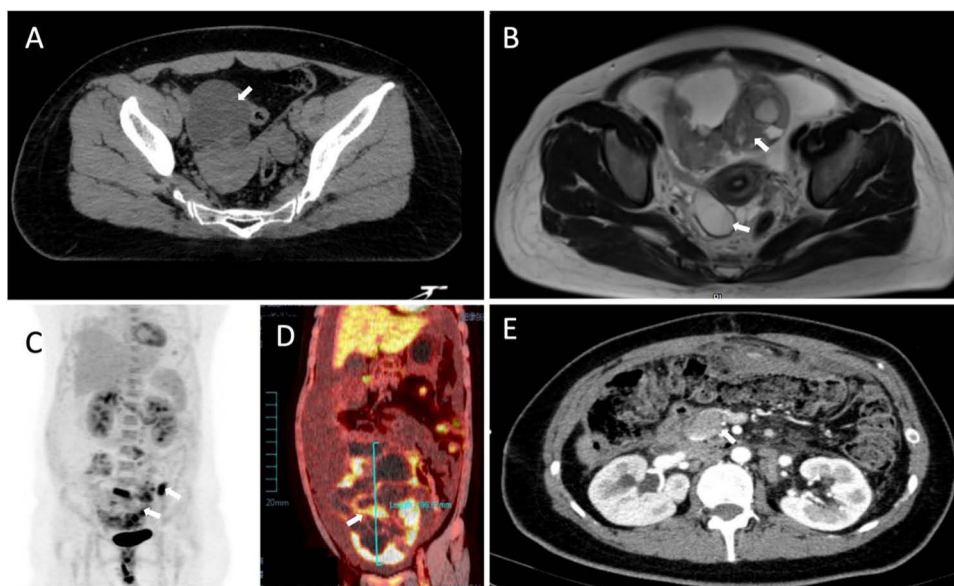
Imaging findings at multiple intervals following initial diagnosis. (A) An unenhanced pelvic CT scan was conducted 15 months post-initial surgery, highlighting a right adnexal cystic-solid mass measuring $7.03 \times 6.30 \times 5.60 \text{ cm}^3$, indicated by the white arrow. (B) A pelvic contrast-enhanced MRI scan was performed 14 months following the second surgical procedure, with the white arrow indicating a sizable abdominopelvic cystic-solid mass accompanied by ascites. (C and D) PET/CT scans obtained 14 months after the second surgery revealed a significant abdominopelvic cystic-solid mass with extensive abdominal metastases and focal bone marrow involvement, as marked by the white arrow. (E) A contrast-enhanced abdominal CT scan, performed 6 months after the third surgical intervention, demonstrated several enlarged retroperitoneal lymph nodes, underscored by the white arrow.
